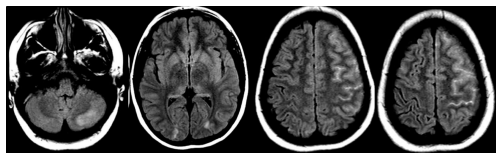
MRI 24 hours after symptoms onset: FLAIR sequence shows hyperintense signals on the left cerebellar hemisphere and in both occipital lobes. cSAH was also observed in left frontal sulci.
